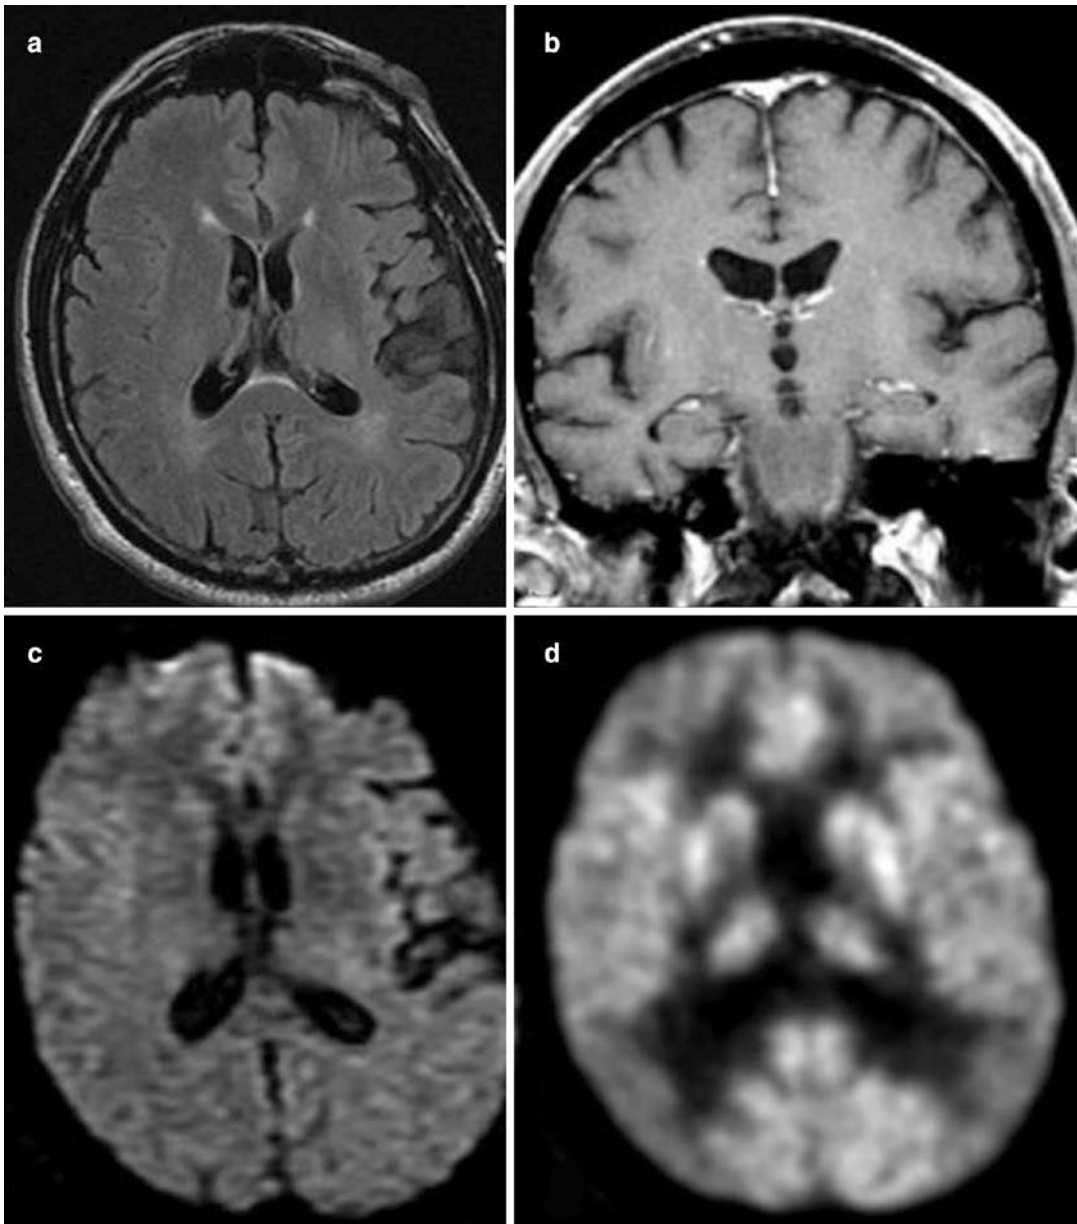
75-year-old male with probable Lewy body disease. Axial FLAIR (a) and coronal T1 (b) show lack of obvious cortical atrophy or vascular brain damage. Trace
